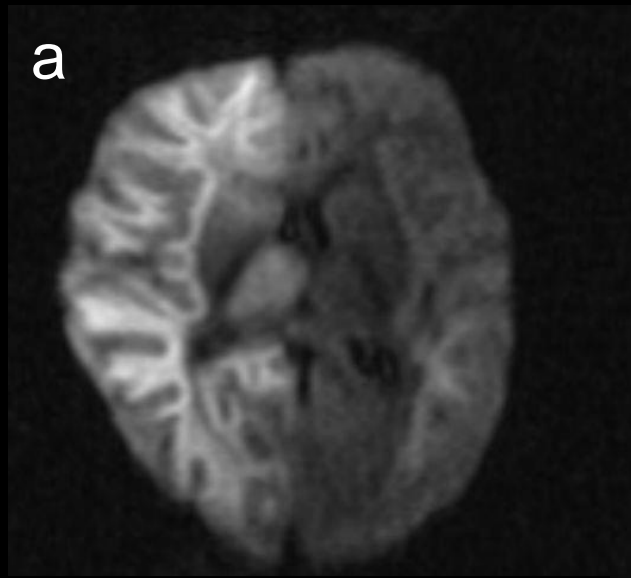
Magnetic resonance imaging with other distribution types of injuries (DWI): a, Patient No. 1. b, Patient No. 4. c, Patient No. 10. d, Patient No. 11. e, Patient No. 13. f, Patient No. 15. g, Patient No. 16. h, Patient No. 17. i, Patient No. 18. j, Patient No. 19. k, Patient No. 22. l Patient No. 23. m, Patient No. 25. n, Patient No. 26. o, Patient No. 34. DWI, Diffusion-weighted imaging
